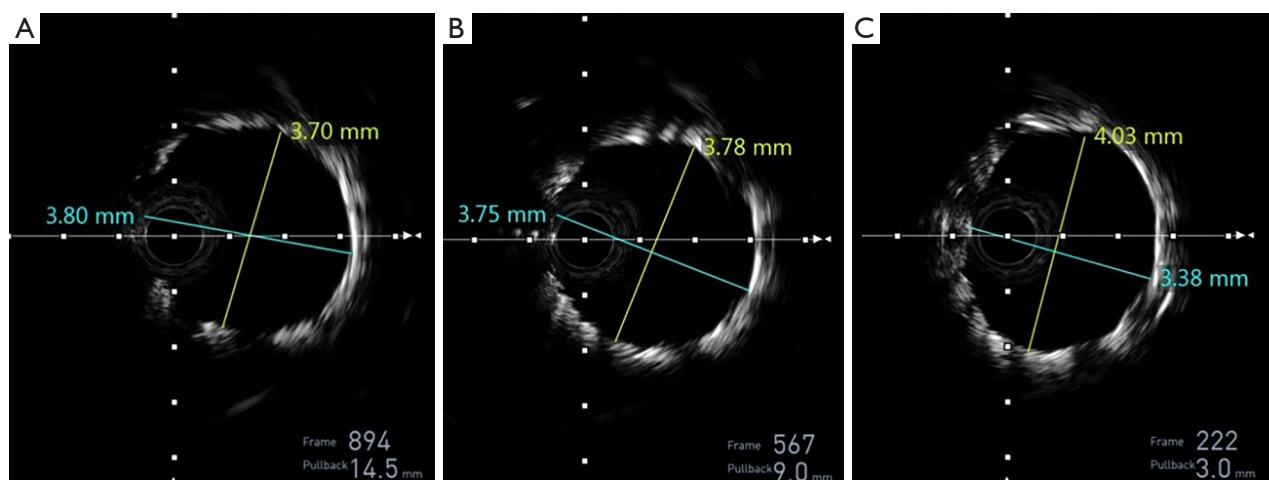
IVUS measurements of the inner diameter of the stent (number 12). IVUS, intravascular ultrasound.
